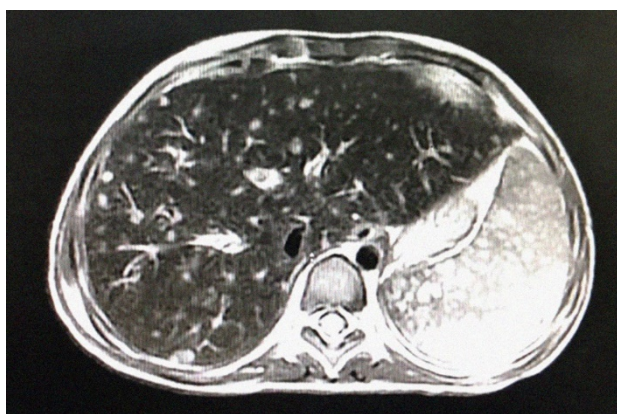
MRI of the abdomen showed an enlarged spleen.
